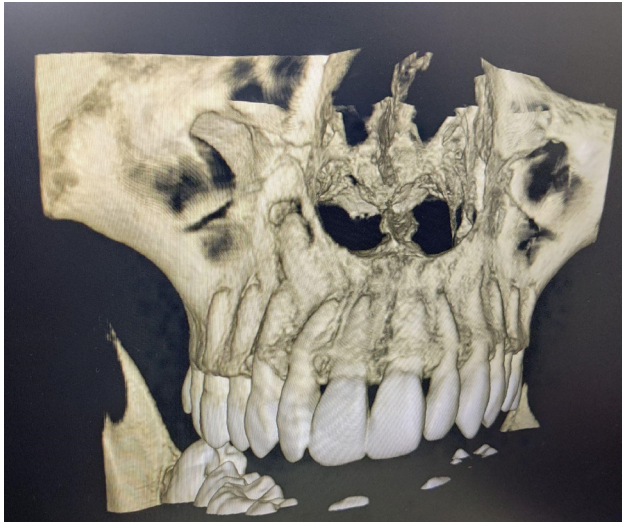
CBCT 3D image - Buccal aspect.
